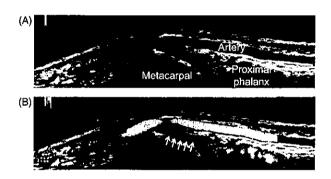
Representative images of reverberation mimicking synovial Doppler signals. Dorsal aspect of the left first metacarpophalangeal joint, longitudinal view. (A) gray-scale image and (B) power Doppler image. Arrows indicate reverberation on the hyaline cartilage due to superficial artery (see also Video 22).
